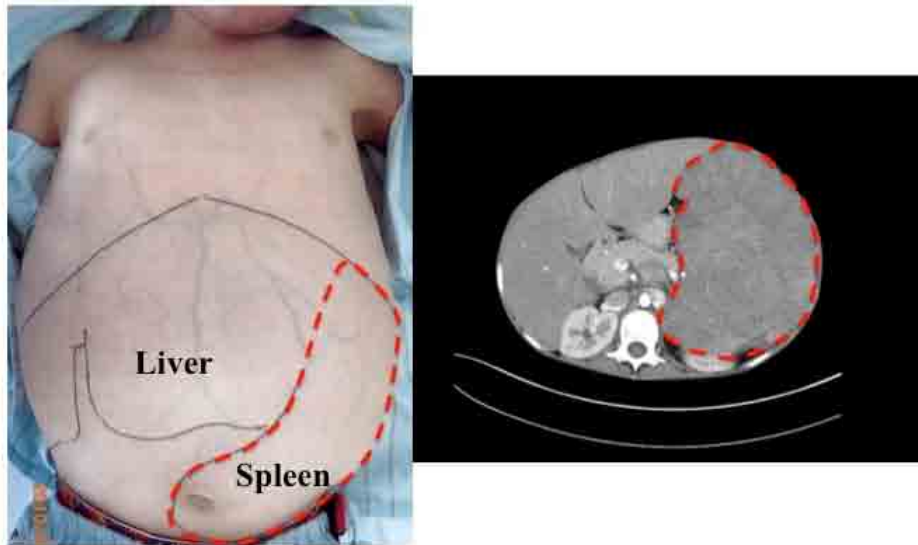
Huge hepatosplenomegaly. Computed tomography revealed an enlarged liver and a huge spleen that occupied a large volume of the abdominal and pelvic cavities.
